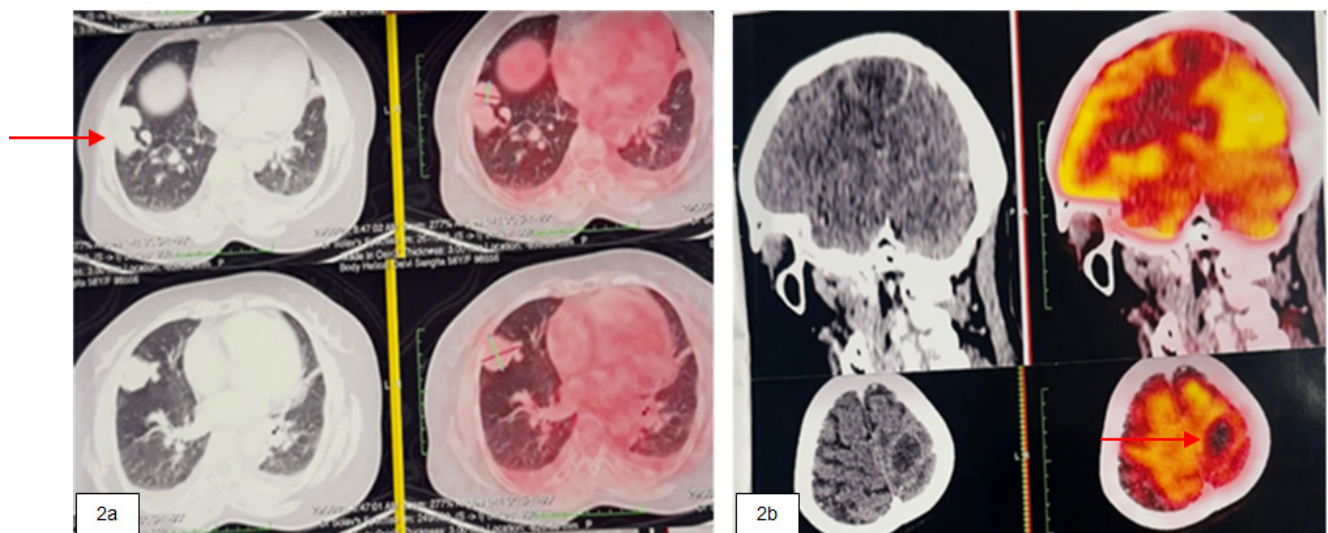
(A)- Axial PET CT image shows weakly metabolic enhancing soft tissue lesion in right lung lower lobe. (B) - Brain lesion appears ametabolic, confirming it to be an abscess
